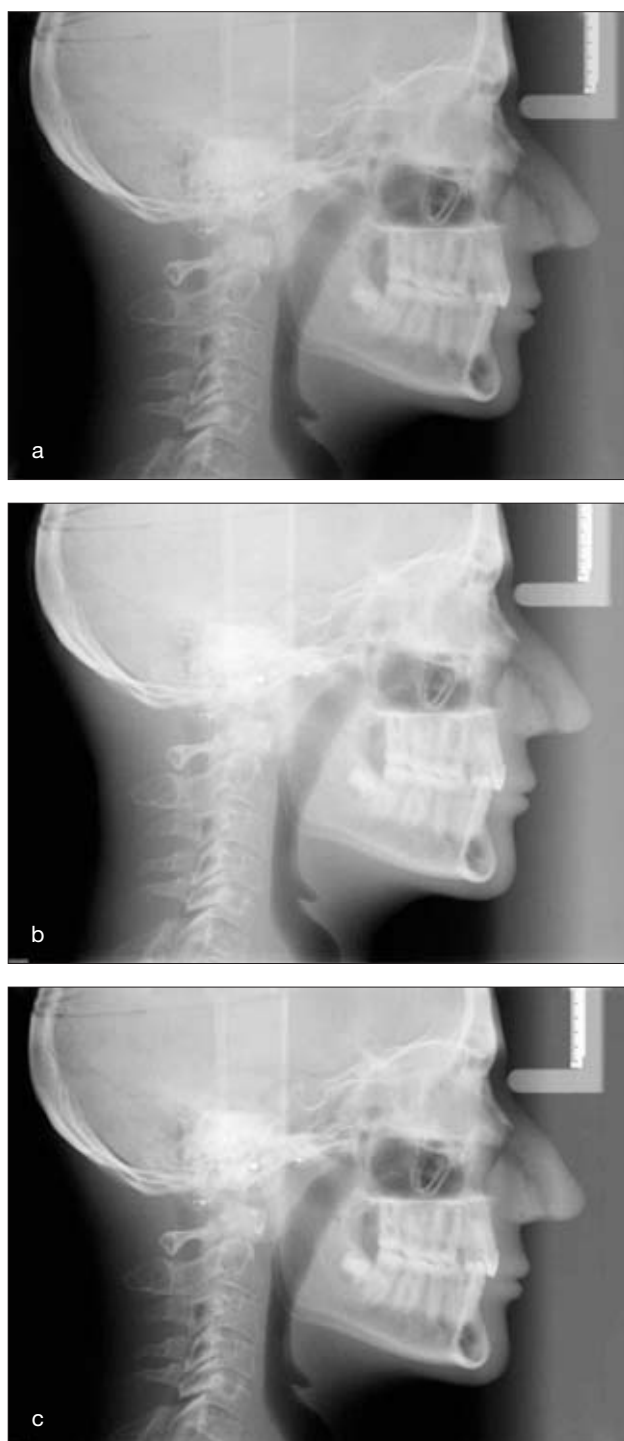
Examples of predicted radiograph (a), non-predicted radiograph (b) and optimal radiograph (c).
